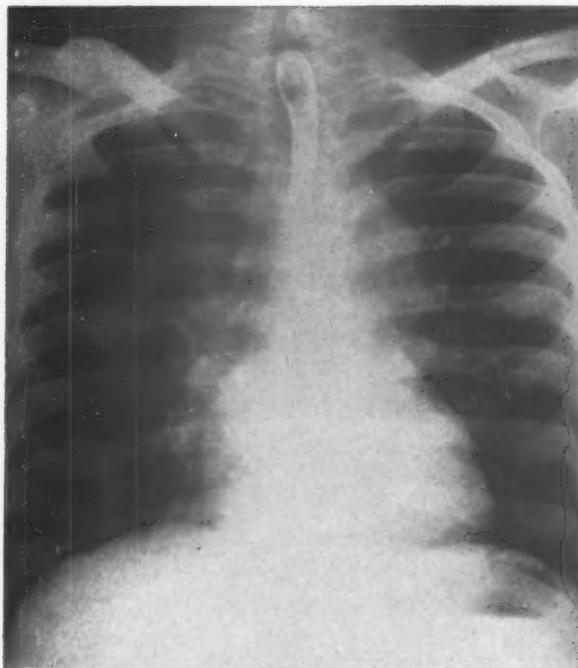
Posteroanterior roentgenogram of the chest following barium swallow, showing aneurysmal dilatation of the aorta in the region of the aortic knob.
